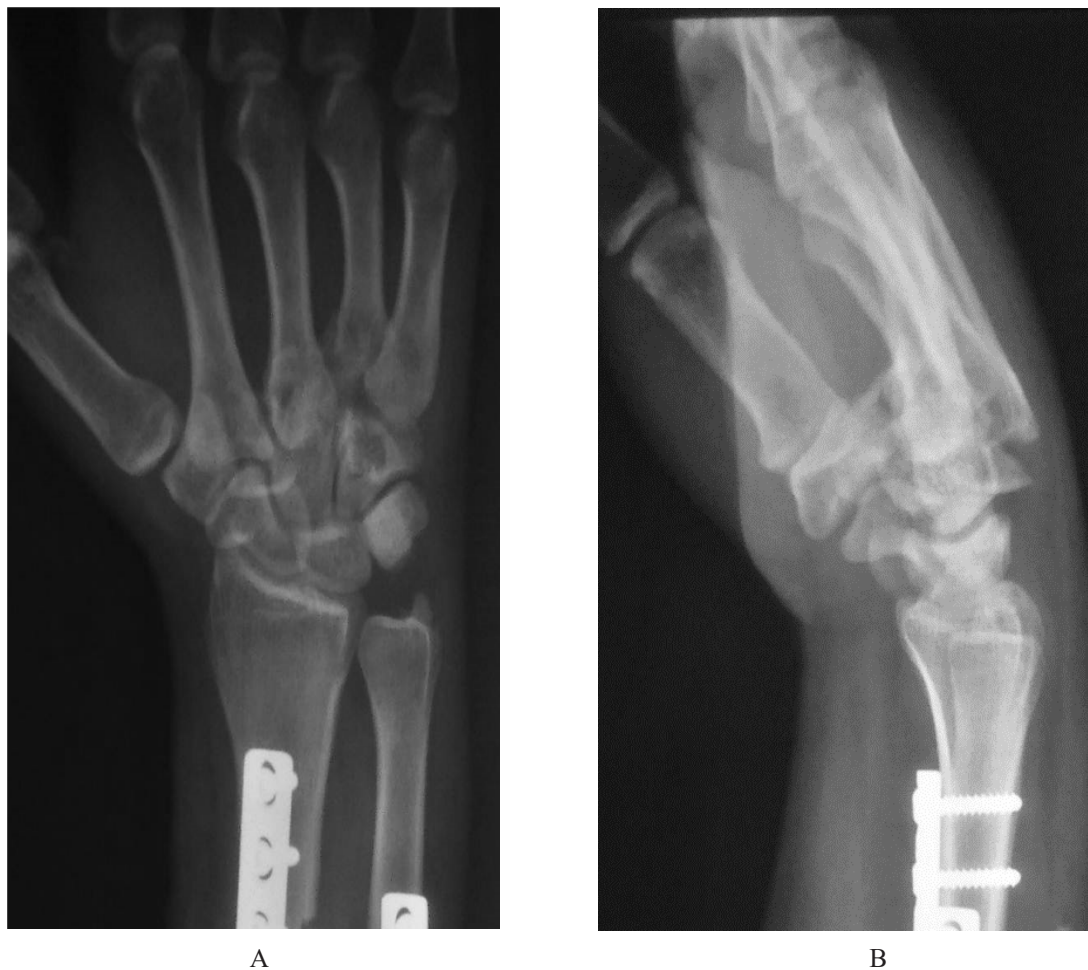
Plain radiographs of the right wrist (A – anteroposterior view; B – lateral view) show CMC joint dislocations of the index, middle and ring fingers
